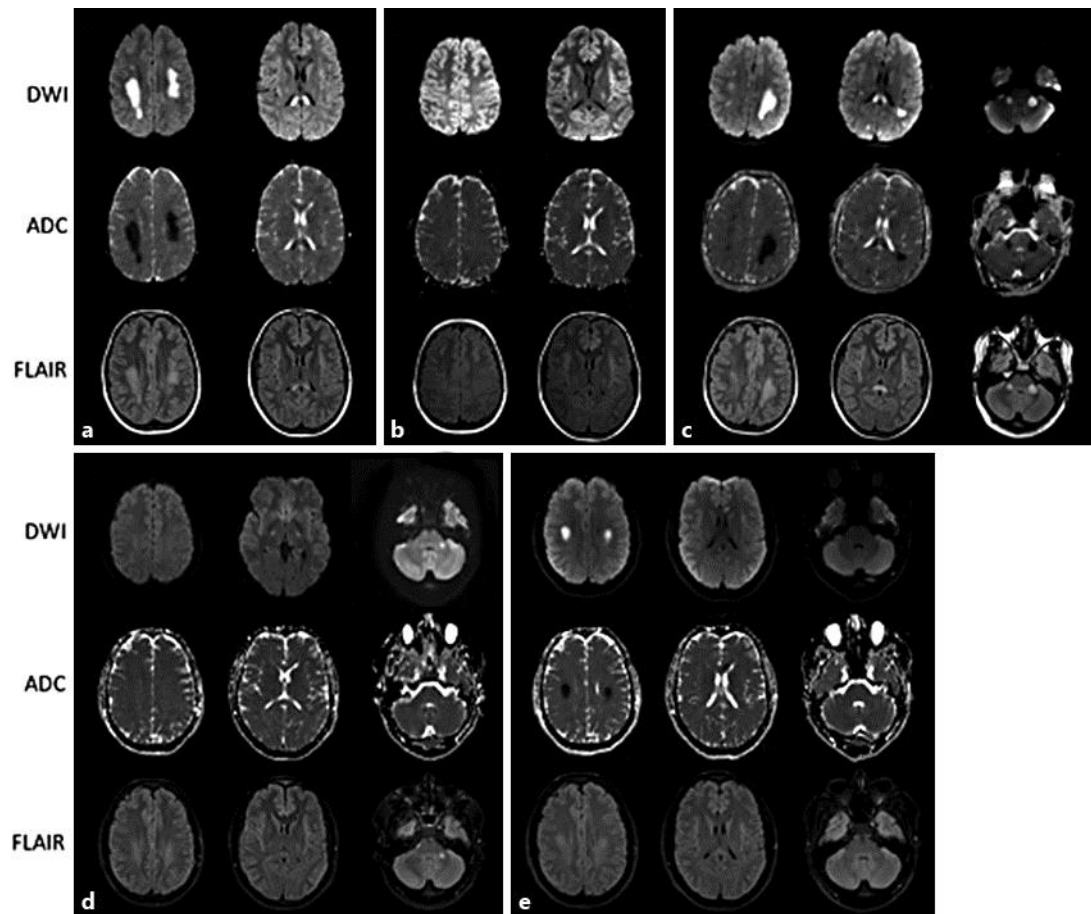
Progression of cerebral white matter lesions associated with CMTX1 in a single patient over 7 years. DWI = Diffusion-weighted imaging; ADC = apparent diffusion coefficient. a Initial presentation in September 2007 associated clinically with right-sided weakness demonstrates diffusion-weighted and FLAIR signal in the left greater than right centrum semiovale and the splenium of the corpus callosum. b Follow-up imaging in December 2007 with near-complete resolution of the DWI and FLAIR hyperintensities. c Second exacerbation of stroke-like symptoms in July 2008 associated with left-sided weakness and large hyperintensities in the bilateral centrum semiovale, corticospinal tracts, splenium of the corpus callosum, and the right cerebellar peduncle on DWI and FLAIR sequences. d Follow-up imaging in December 2011 demonstrates resolution of lesions in the right cerebellar peduncle, bilateral centrum semiovale, and splenium of corpus callosum, with a residual small area of FLAIR hyperintensity in the left cerebellar peduncle. e Presentation in November 2014 with dysarthria, left-sided weakness, and dysesthesia demonstrating restricted diffusion and FLAIR hyperintensity in the right greater than left corona radiata and left genu of the corpus callosum. The previously visualized signal in the left cerebellar peduncle has resolved.
